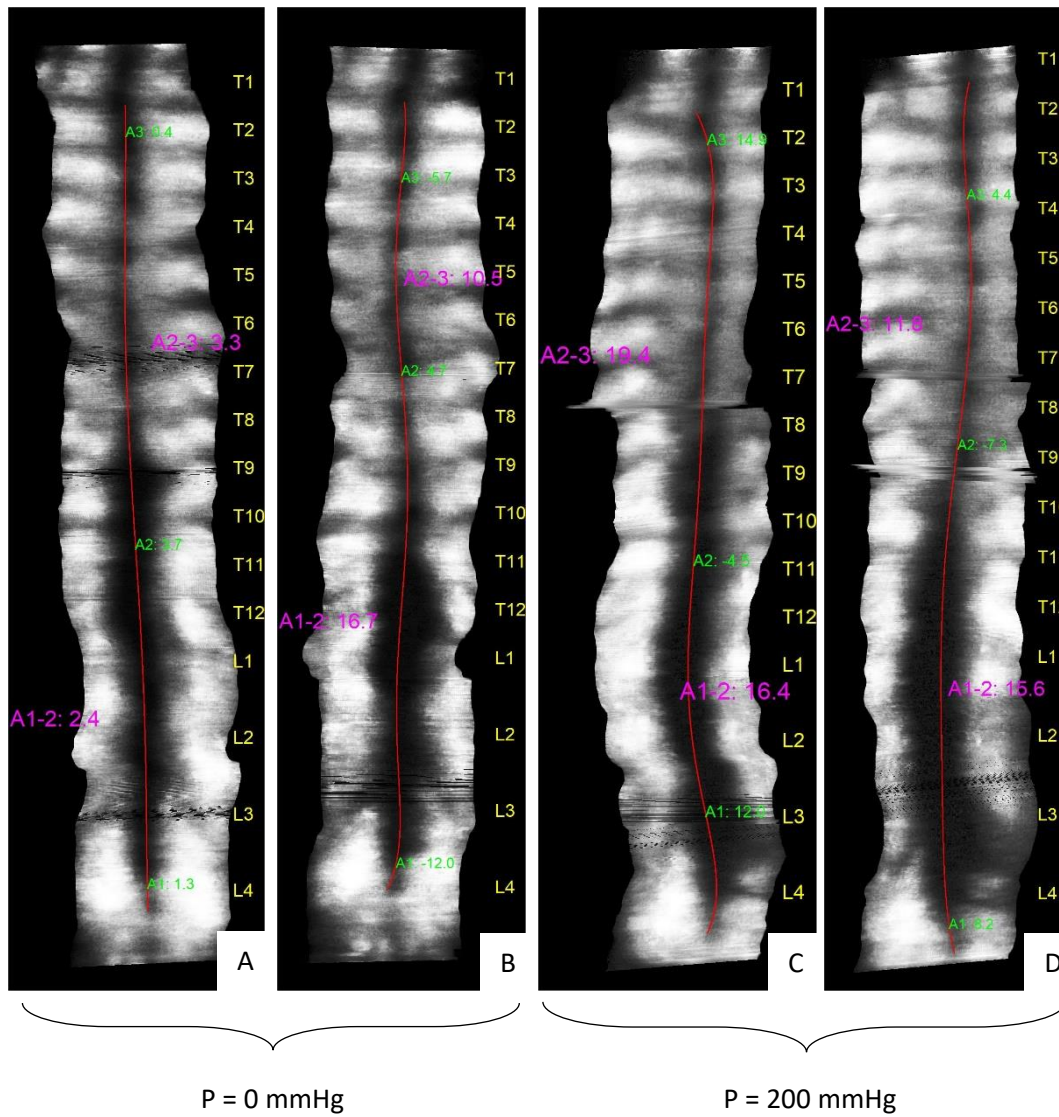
Posterior view of ultrasound image results, image A-B and C-D were taken right after each other. Pressures are applied in the same direction as figure 15. A1-2 represents the thoracolumbar curve, A2-3 represents the thoracic curve.
